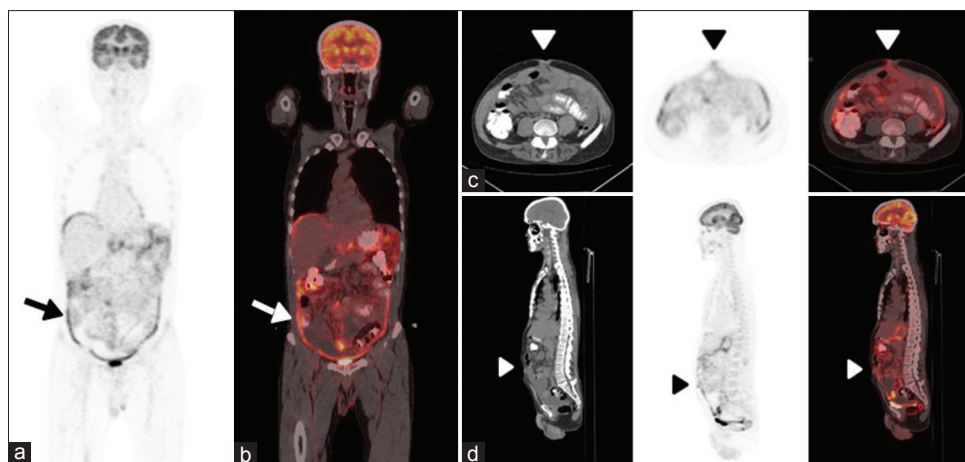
Abdominal computed tomography showed the presence of ascites, peritoneal thickening, and omental cake sign, and peritonitis carcinomatosa was suspected. Fluorodeoxyglucose positron emission tomography/computed tomography revealed massive peritoneal involvement with high-fluorodeoxyglucose uptake (maximum standardized uptake value, 6.3; arrows) and a hypermetabolic nodular lesion in the periumbilical region (maximum standardized uptake value, 3.3, arrowheads) [Figure 1]. Multiple hypermetabolic lymph nodes, pleural effusion, and mild fluorodeoxyglucose uptake in pleural surfaces were also seen. Maximum intensity projection (a), coronal (b), axial (c), and sagittal (d) positron emission tomography/computed tomography images are given in the figure
